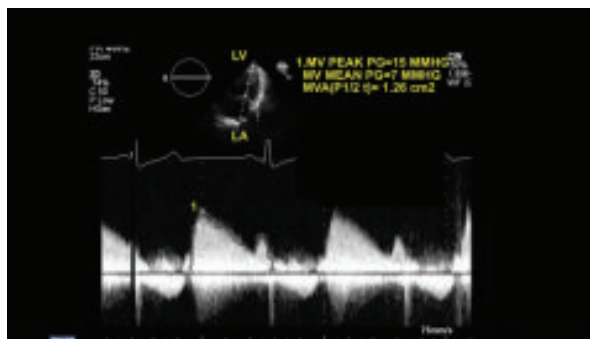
Two -dimensional transthoracic echocardiography. Mitral stenosis. Continuous wave Doppler of mitral valve (MV) shows peak and mean pressure gradients (PG) of 15 and 7 mmHg, respectively and mitral valve area (MVA) of 1.26 cm² by pressure half time (P 1/2t) method consistent with moderate mitral stenosis.
